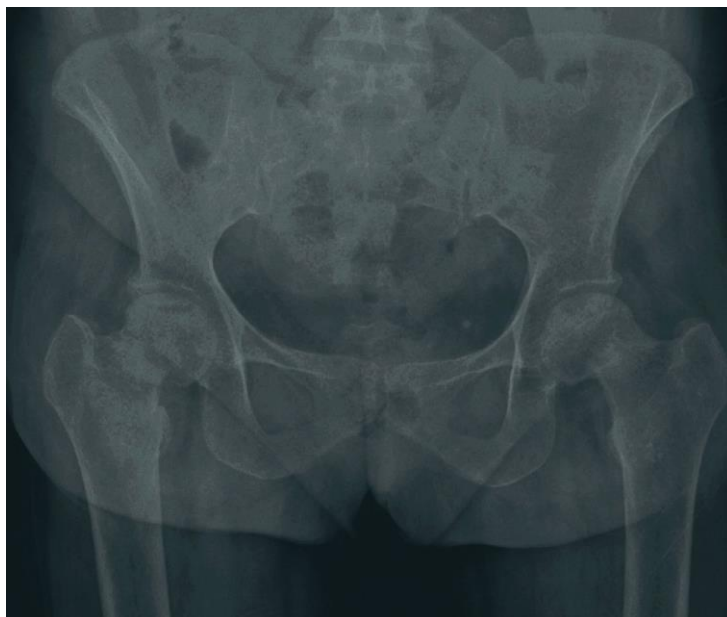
A pelvic X-ray demonstrating widespread osteopenia in femoral neck
